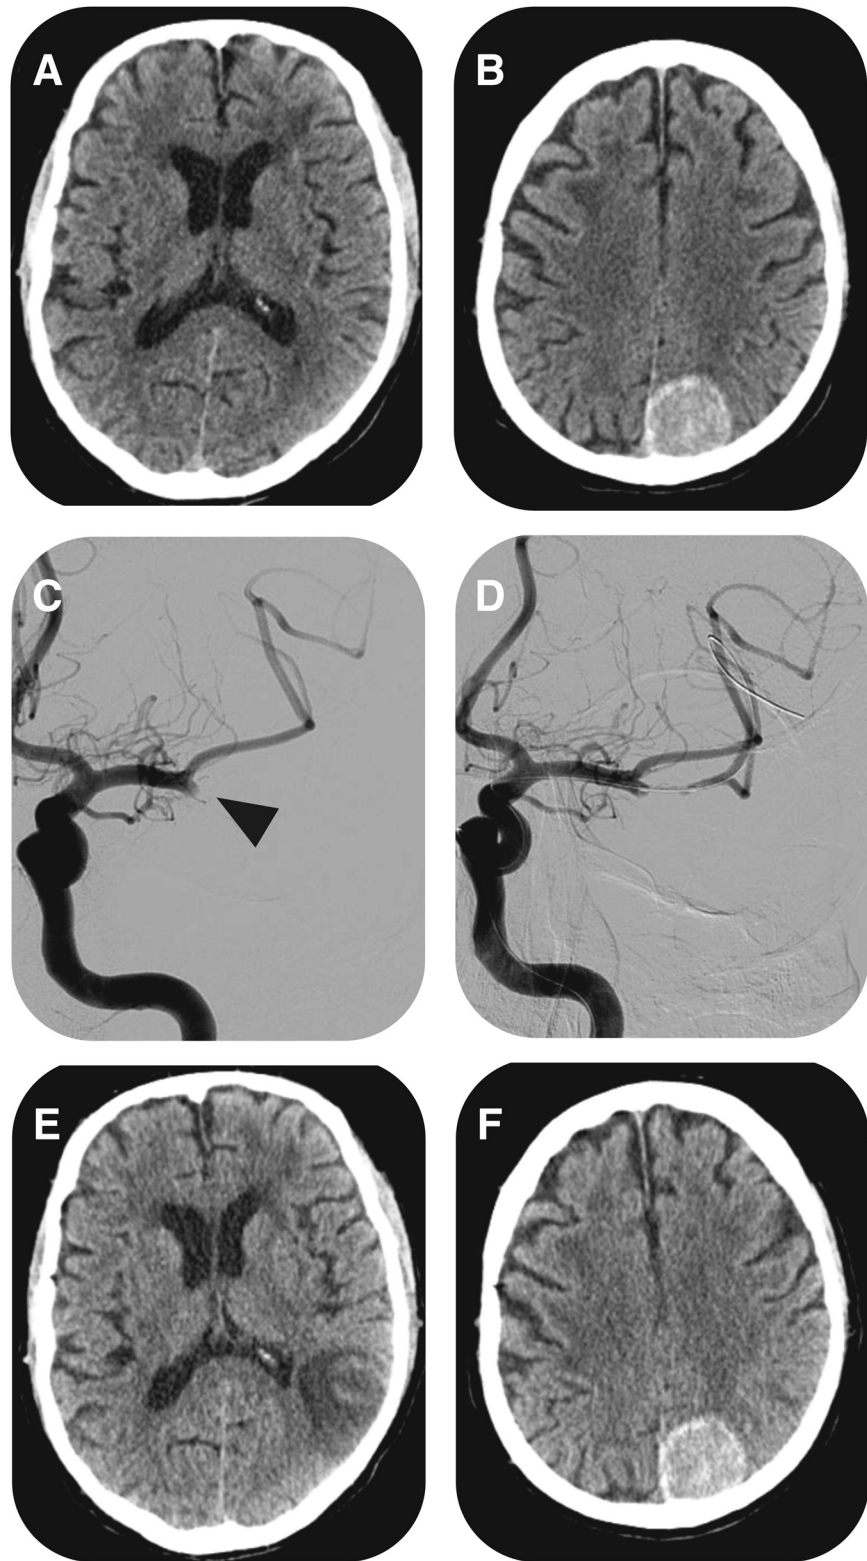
The first computed tomography (CT) scan (1 hour 40 minutes after onset) showed a calcified left occipitoparietal meningioma and no acute abnormalities (A and B). The cerebral angiogram showed occlusion of the inferior division of the left middle cerebral artery (C). Intra-arterial administration of .3 mg/kg of recombinant tissue plasminogen activator combined with mechanical thrombolysis resulted in partial recanalization (D). The CT scan 24 hours after the procedure showed a parietal ischemic area and no bleeding complications (E and F).
